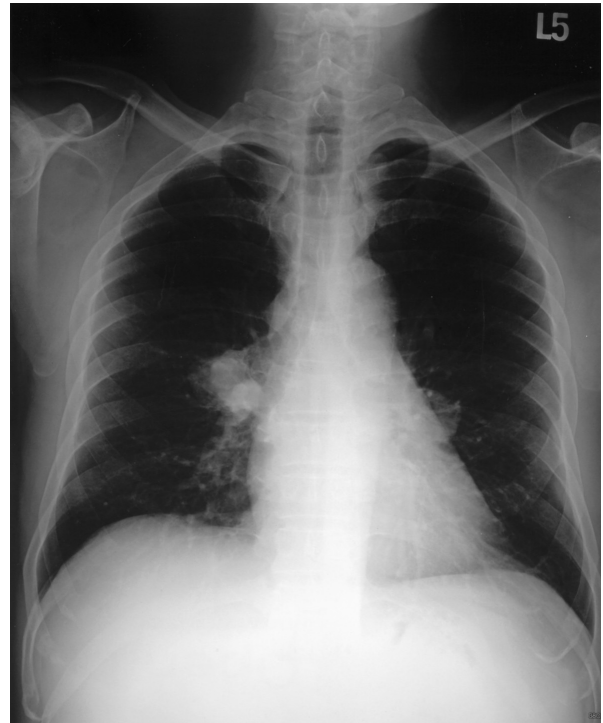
Chest radiograph, posterior-anterior view, showed a lobulated mass near the right hilum and a round nodule adjacent to the left hilum.
